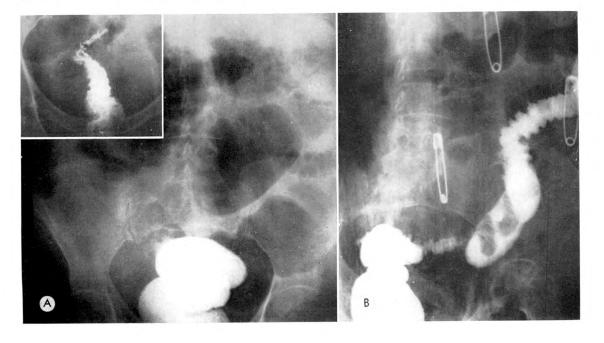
Case No. A9673. Sixty-five year old male with a chief complaint of bleeding by rectum. (A) Attempts at administration of barium enema were unsuccessful. (B and C) After 40 per cent hypaque was administered by mouth, the colon was adequately delineated. Note multiple diverticula at various levels. Roentgenograms were made at 4 and 5 hours respectively.
